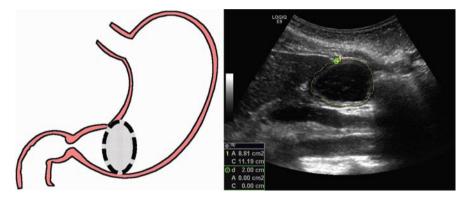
2D sagittal ultrasound image of the antrum
